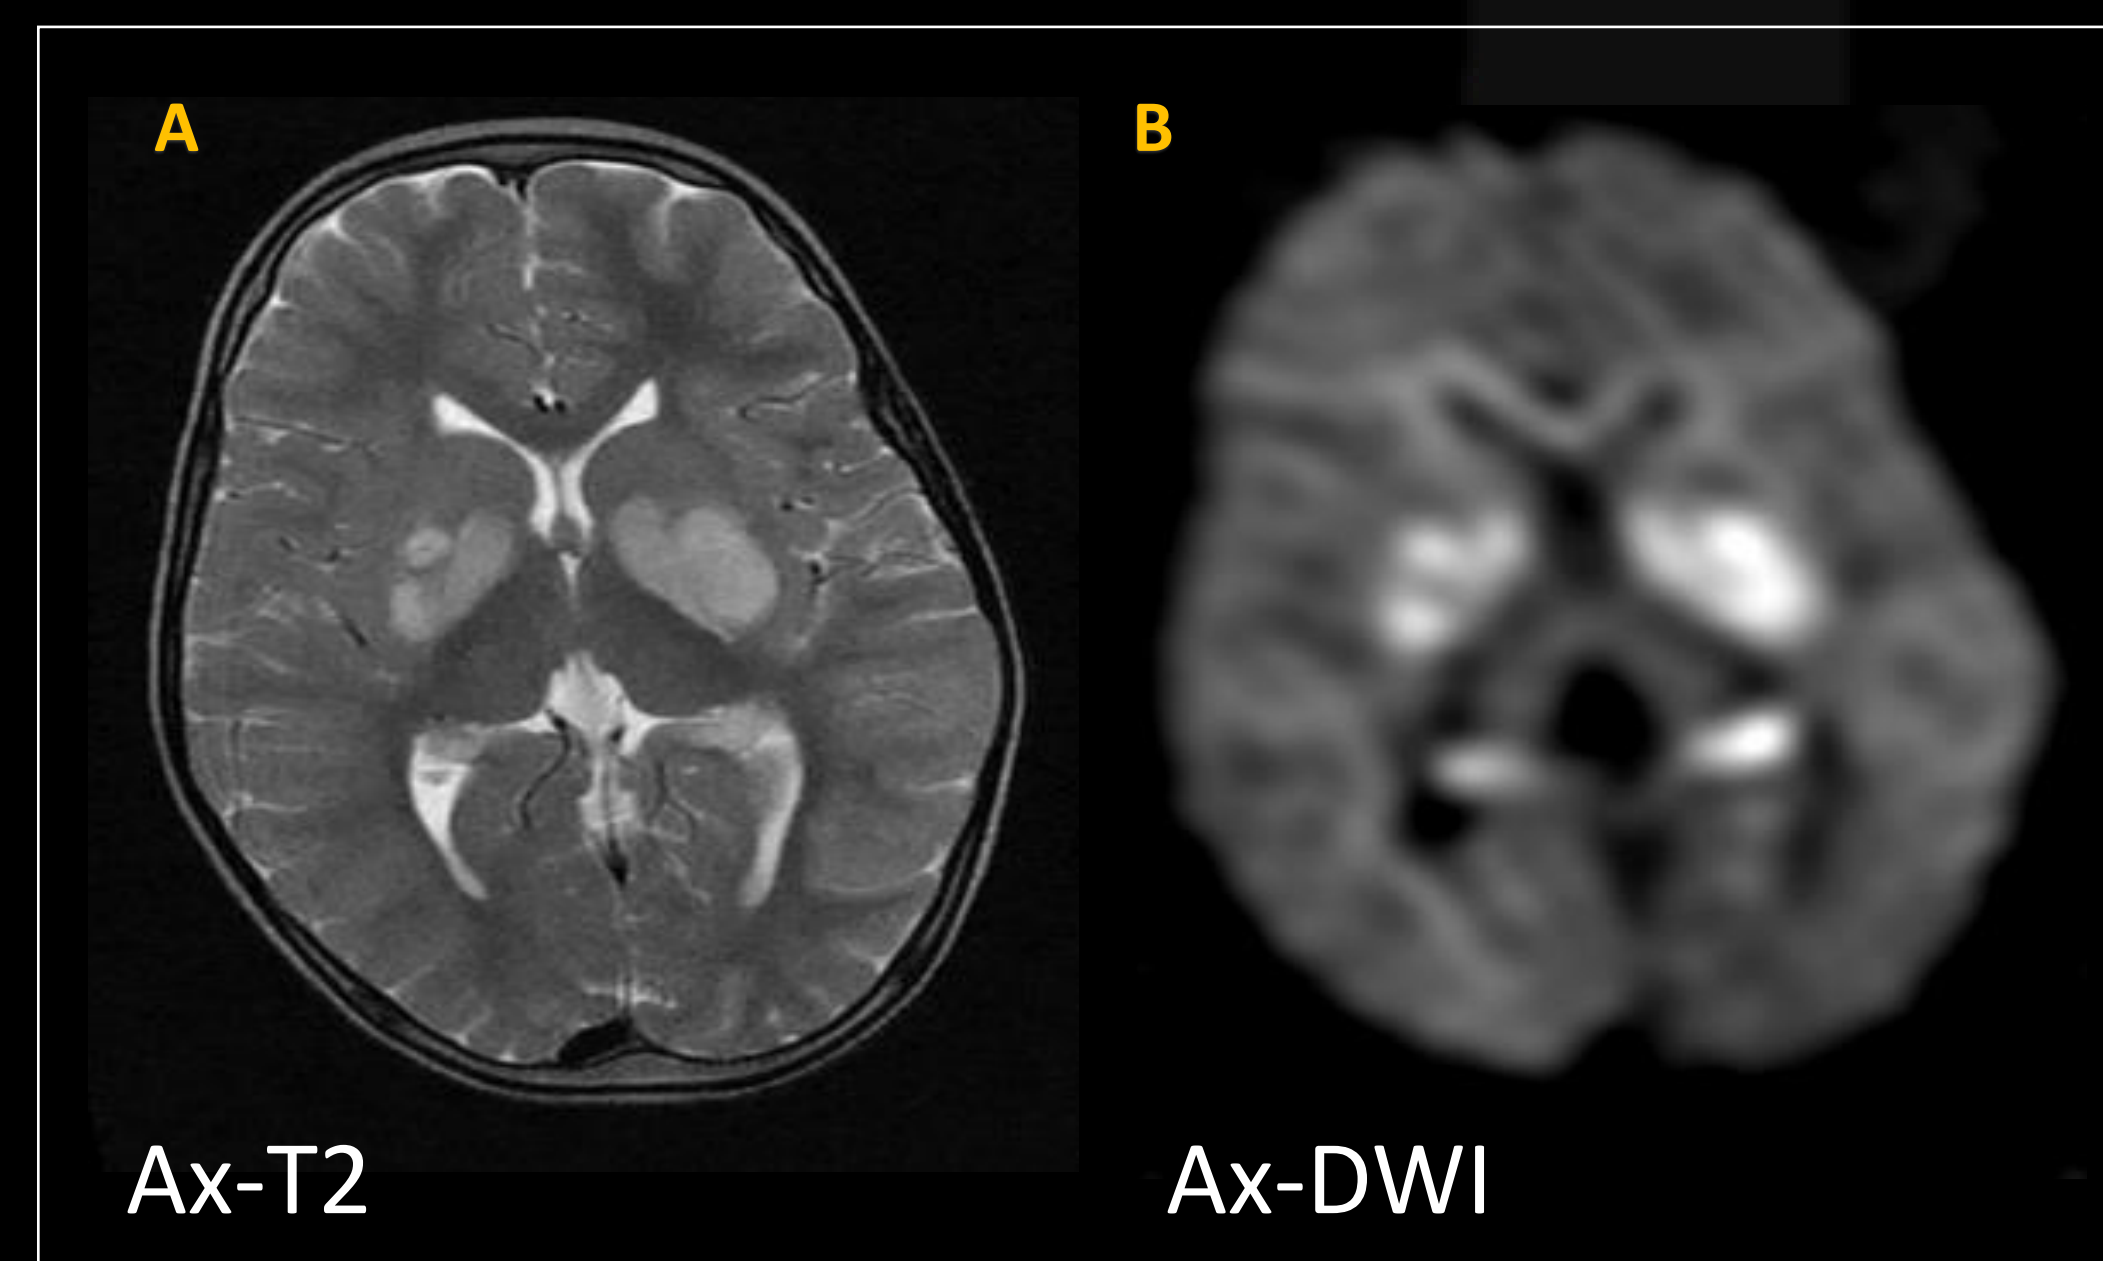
Axial T2W and DWI images through the basal ganglia demonstrating increased signal in bilateral lentiform nuclei and hippocampi.
